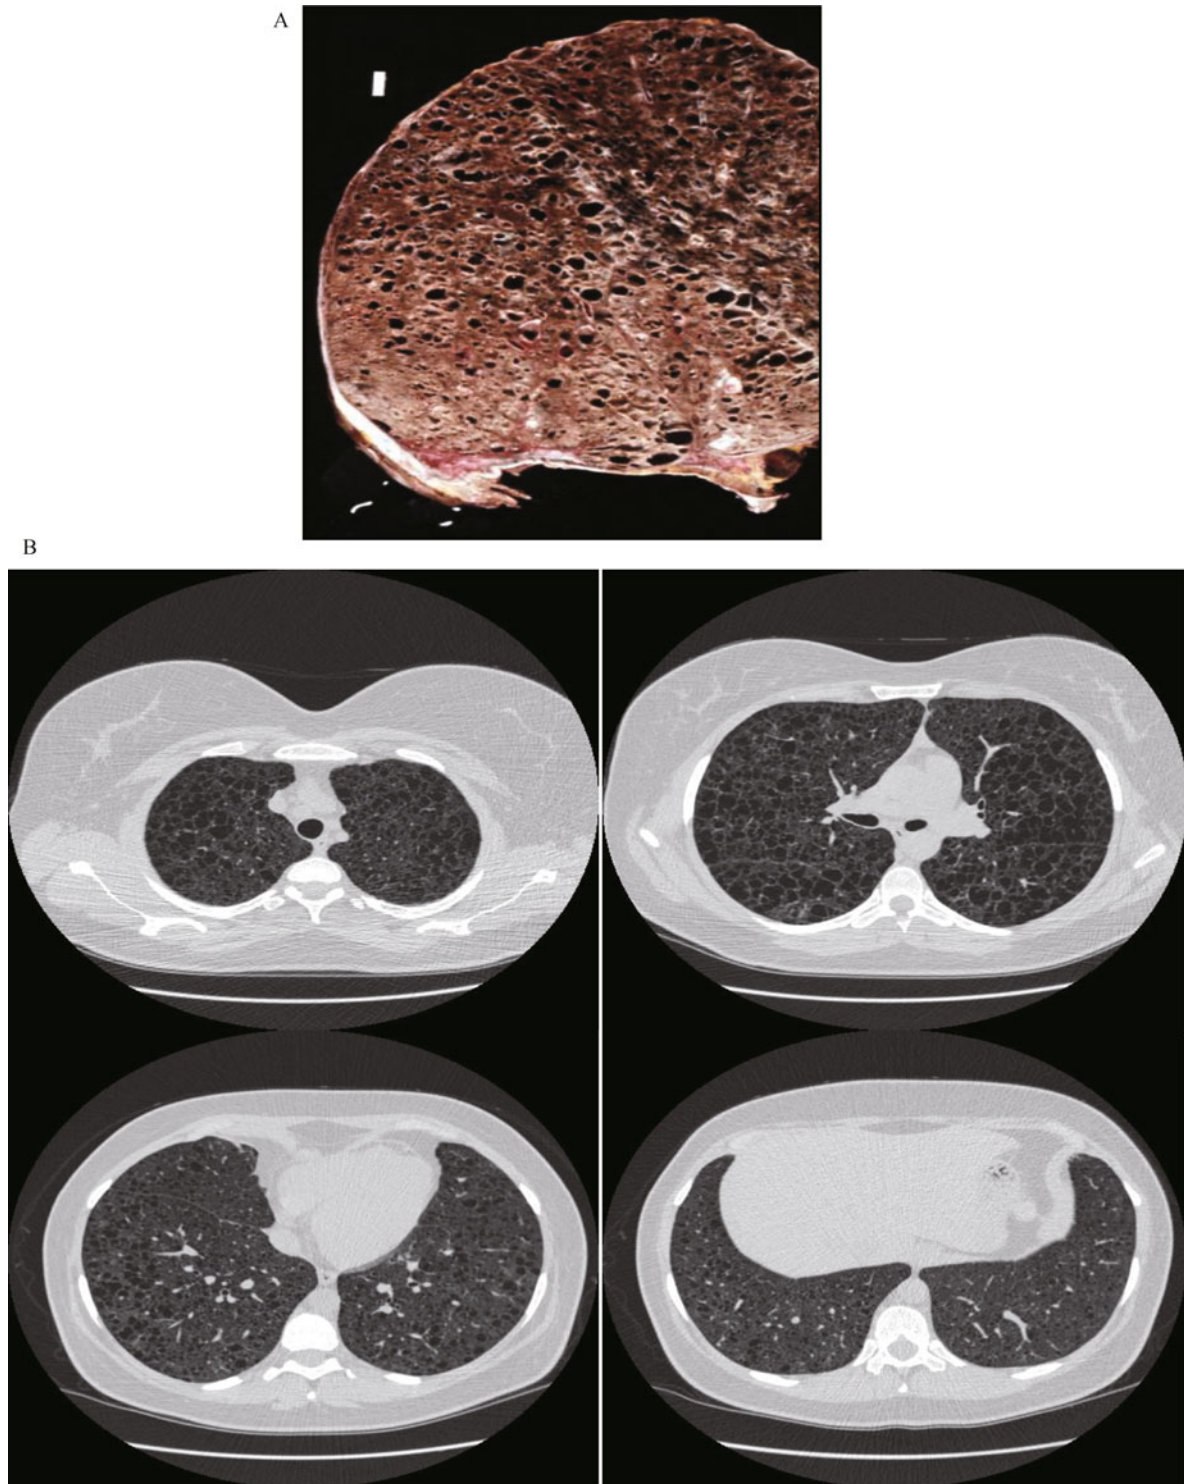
(A) Gross pathologic image of LAM lung. Grossly, LAM lungs are enlarged and diffusely cystic, with dilated airspaces as large as 2.0 cm in diameter. (B) HRCT showing diffuse thin walled cysts in a patient with LAM. Diagnosis was confirmed with transbronchial biopsy.
